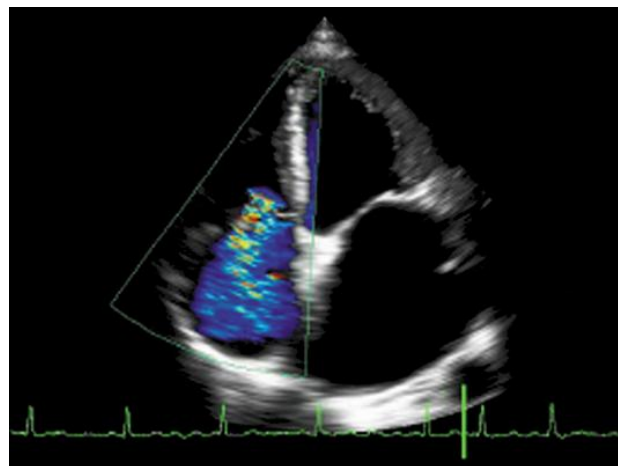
Colour Doppler demonstrating a severe tricuspid regurgitation.
